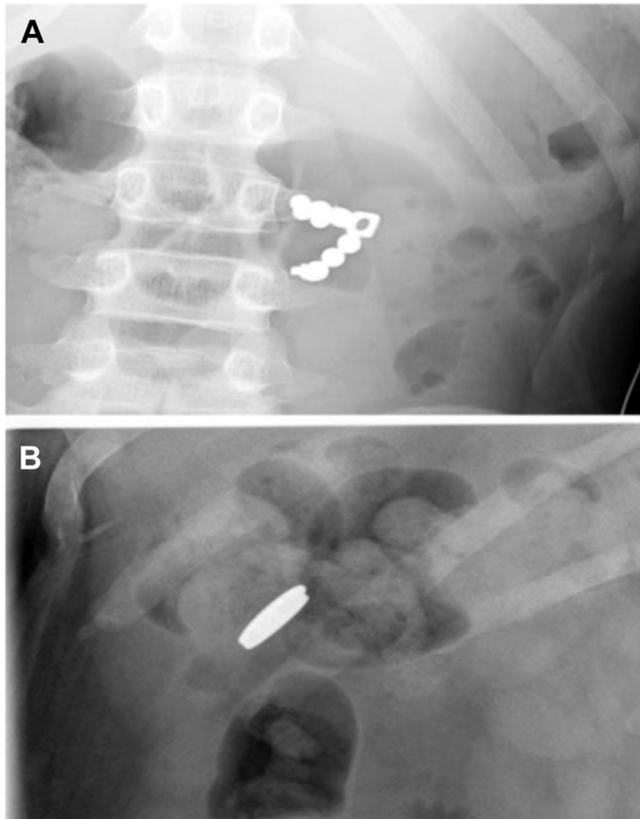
Magnets. *A*, Single supine view of the abdomen, with a string of connected radiopaque beads, compatible with magnets. A radiographic mimic would be an intact metallic beaded bracelet or necklace. *B*, Two adherent platelike magnets.
